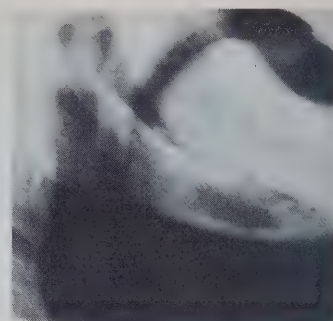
Case 2: Radiograph of mandible with radiolucent lesion near lower border.
